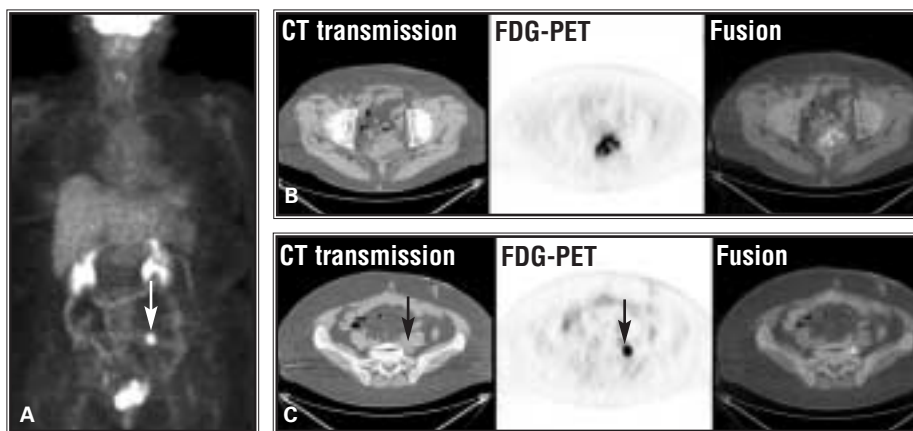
A 61-year-old woman with a history of sigmoid colectomy for colon carcinoma presented with pelvic pain. She underwent PET/CT imaging to assess local recurrence and restaging. A: FDG-PET maximum intensity projection image demonstrates FDG uptake in posterior lower pelvis masked by the bladder on anterior projection, which is displayed, and a focus of FDG uptake in left upper pelvis (arrow). B: Transaxial views just above the bladder and through upper portion of the focus of FDG uptake in lower posterior pelvis demonstrate that the focus of FDG uptake corresponded to a presacral mass in region of anastomosis indicating local recurrence. C: Transaxial views through focus of FDG uptake in left upper pelvis demonstrate that the focus of FDG uptake corresponded to a left presacral lymph node, indicating a lymph node metastasis (arrow). This lymph node was detected only retrospectively on the CT images. The finding of a metastatic lymph node in addition to local recurrence has an impact on management of the patient.
